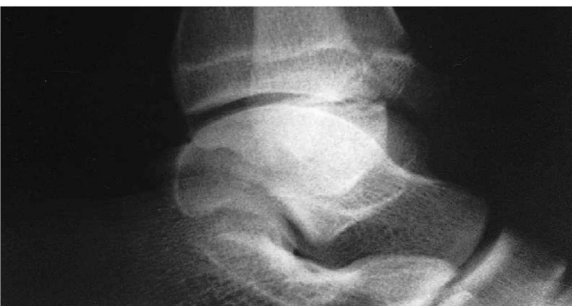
Pre-operative lateral X-ray ankle joint view showing displaced Tillaux fracture.
